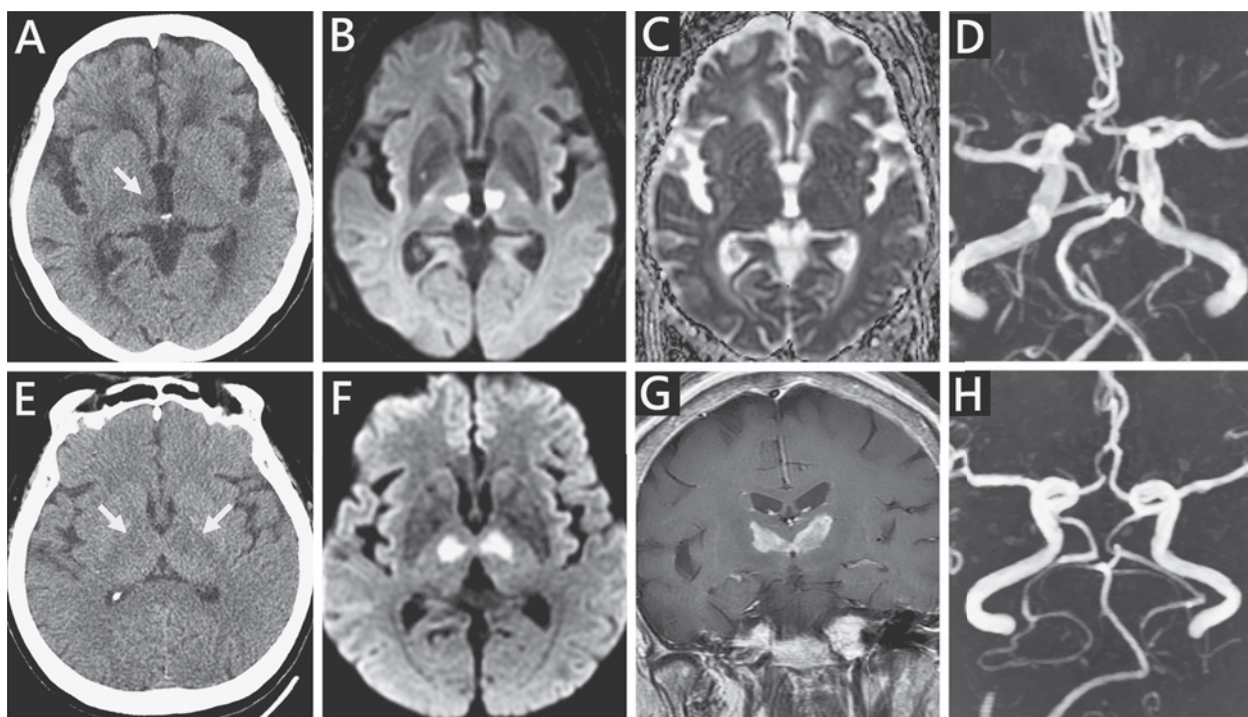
Brain imaging studies of patients 1 (A-D) and 2 (E-H). (A) and (E) Axial brain computed tomography (CT) images revealing small hypodense lesions in the paramedian thalamus (arrows). (B) and (F) Axial magnetic resonance (MR) images revealing acute infarctions in the bilateral paramedian thalami as high-intensity lesions in diffusion-weighted images. (C) Axial MR images of patient 1 revealing acute infarctions in the bilateral paramedian thalami as low signals in apparent diffusion coefficient images. (G) Coronal T1-weighted images with contrast enhancement of patient 2 revealing a "V"-shaped enhanced lesion of bilateral paramedian thalamic infarcts. (D) and (H) MR angiography results revealing no vasospasm in both patients with the fetal-type left posterior cerebral artery (in patient 1) and dominant left posterior cerebral artery (in patient 2).
